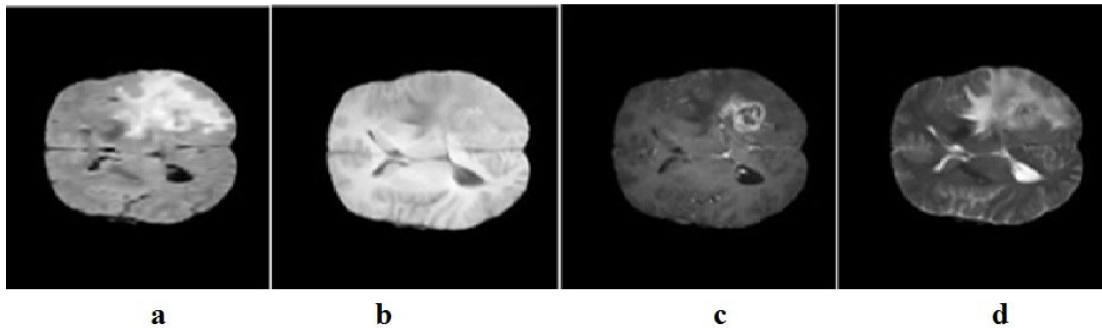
a. FLAIR image b. T1 image c. T1 contrast image d. T2 image
